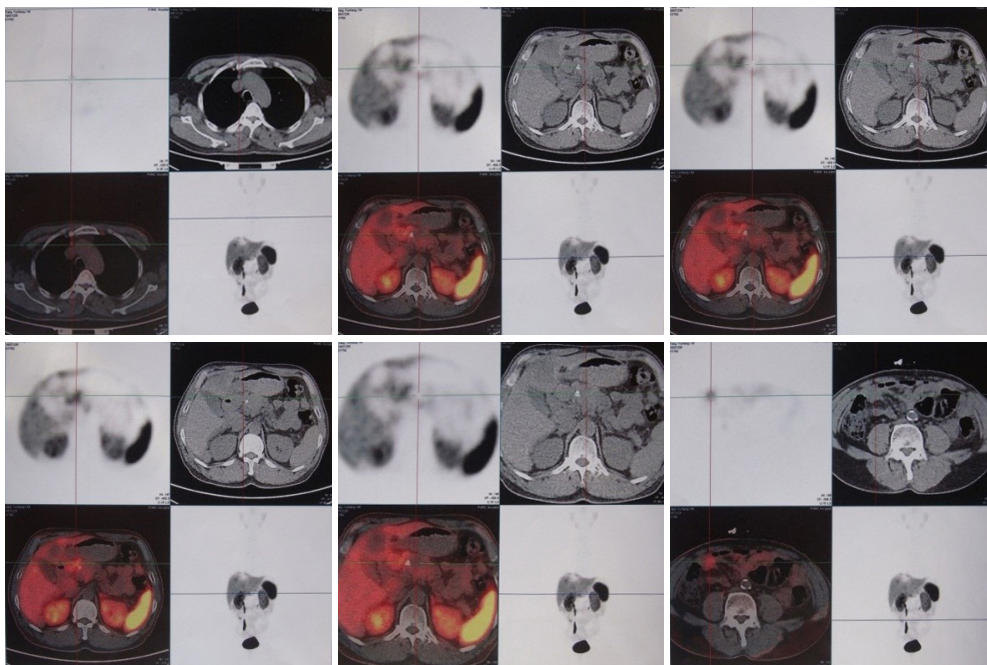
PET-CT (gallium-68) on December 26, 2013.
